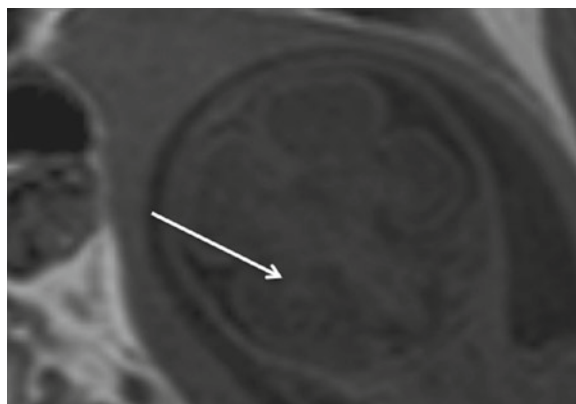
Coronal T1-weighted sequence of a fetus (24+0 GW). The hippocampus appears as a hyperintense structure (white arrow)
